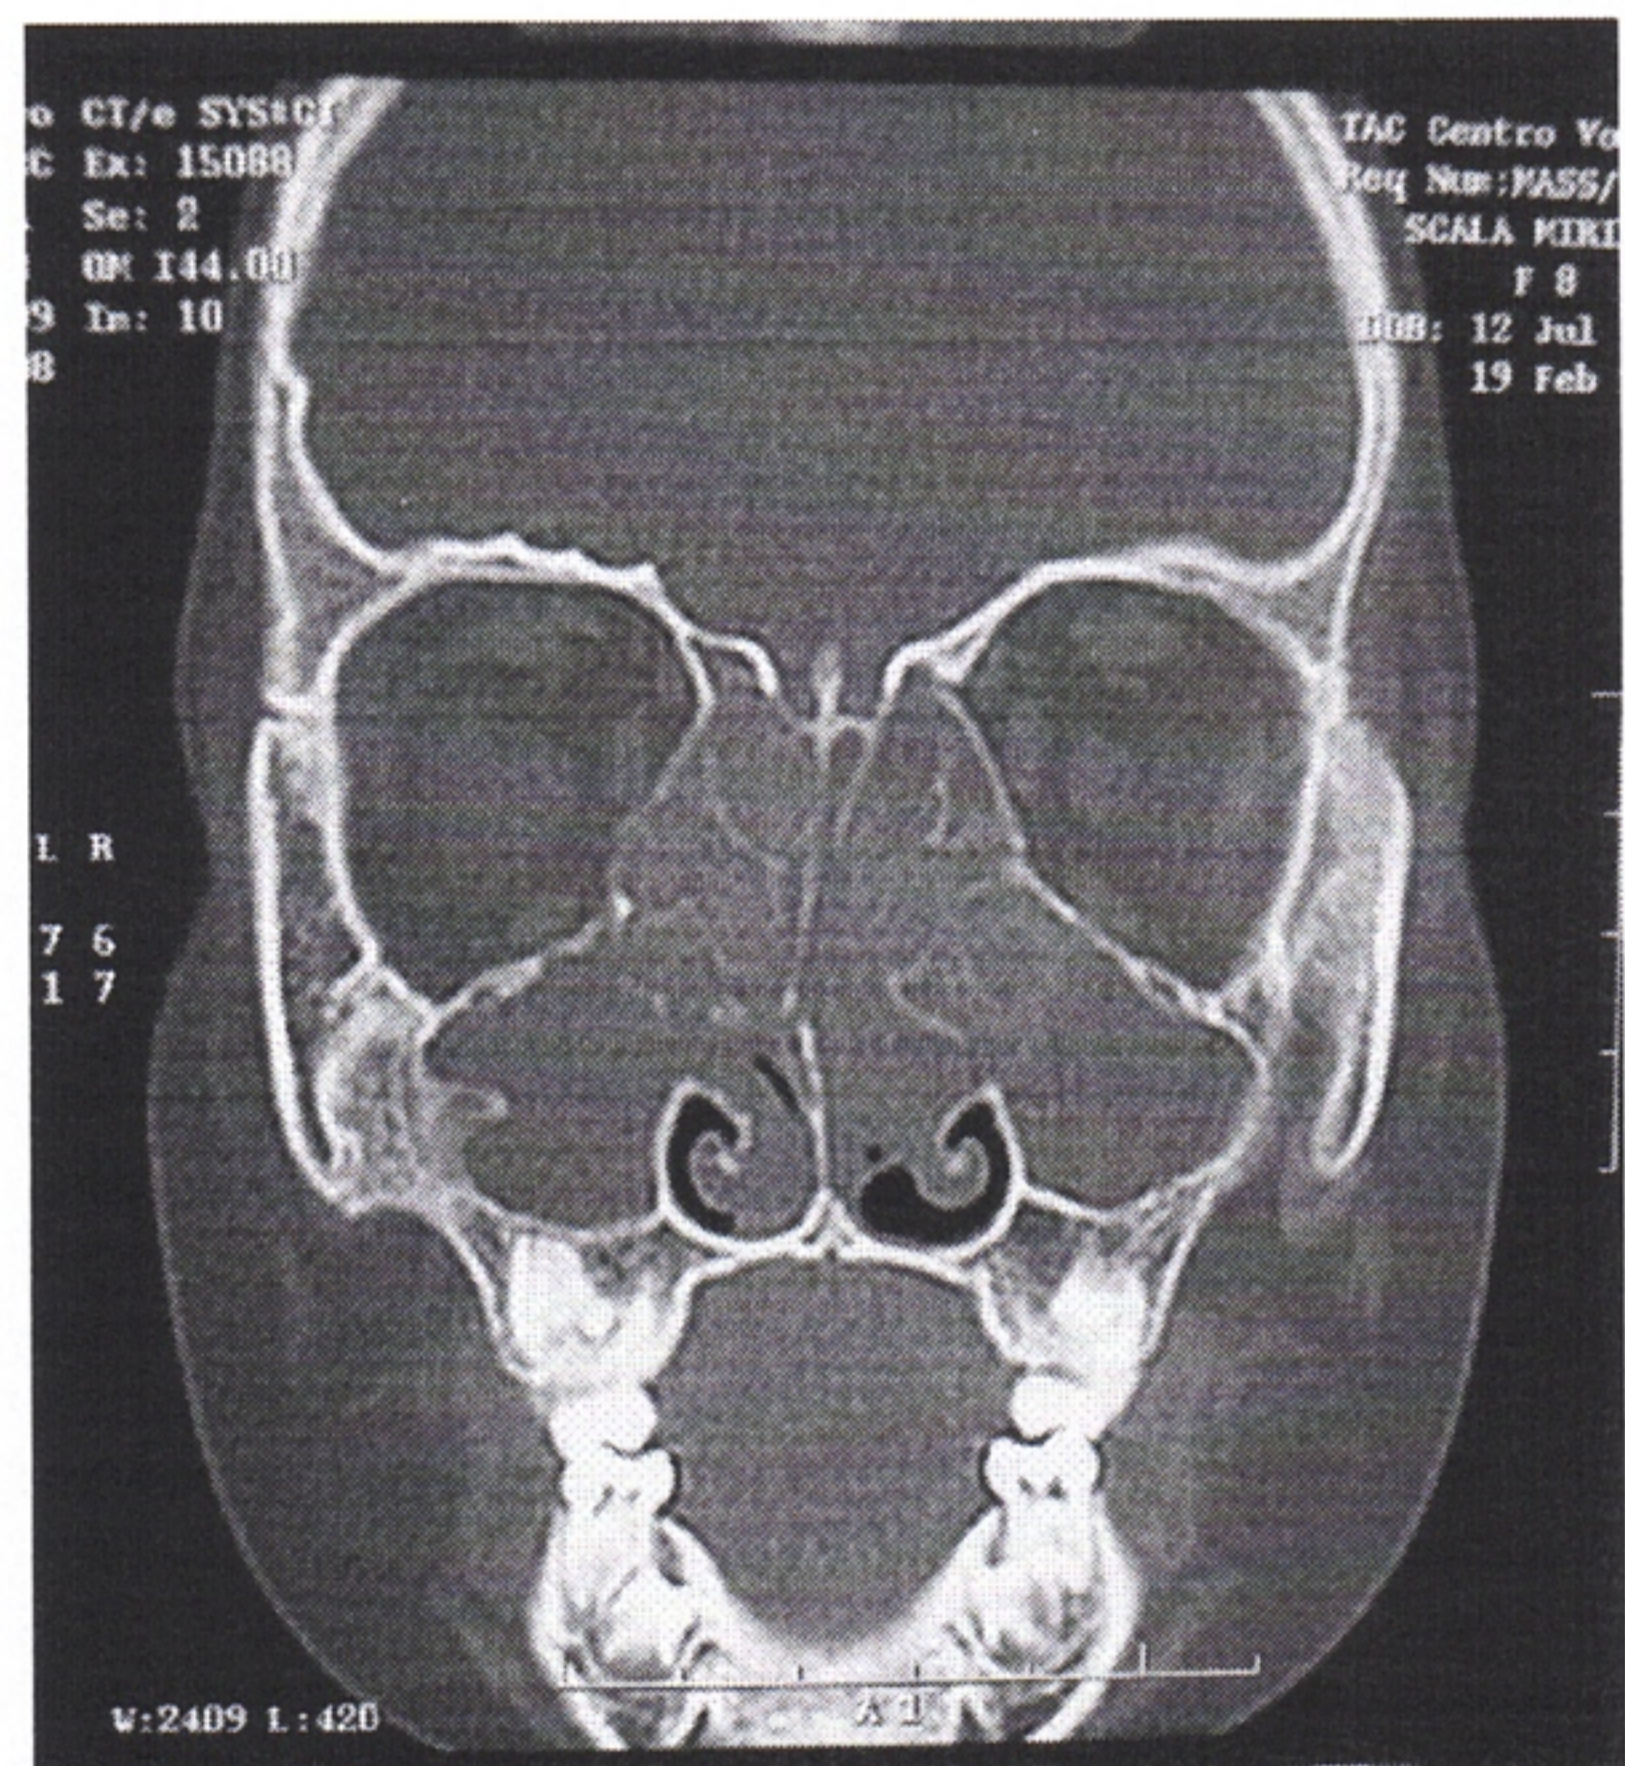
Paranasal sinus computed tomography (CT) shows massive polyposis completely obstructing bilateral nasal cavities, maxillary and ethmoid sinuses.
